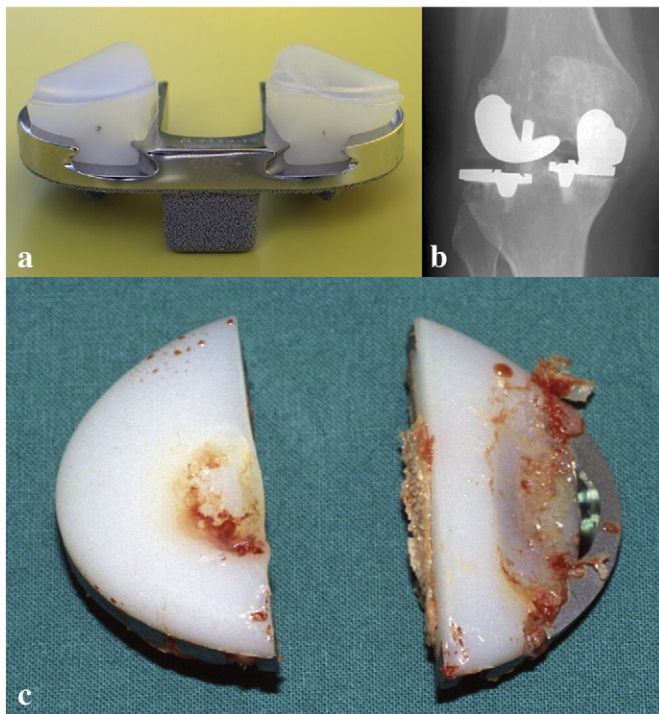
Current approaches to retain both cruciate ligaments in total knee arthroplasty (Nowakowski et al., 2012b): a) LCS® bicruciate retaining prosthesis as an example of a PCR prosthesis derivative: fixation is not as good as in traditional PCR prostheses because of the lack of a central stem. Only short anchoring wings can be used. b) Radiograph of a knee treated with 2 unicondylar knee prostheses: even when optimal alignment of the joint surface levels and malalignment of the components. Such unfavorable loading and abrasion can lead to increased PE wear. c) Explant from Fig. 1b: the medial PE inlay was completely eroded after just 6 years and revision arthroplasty was required (Nowakowski, 2006). Reprinted by courtesy of the Medical Literary Publication Society (Medizinisch Literarische Verlagsgesellschaft mbH), Uelzen, Germany.
